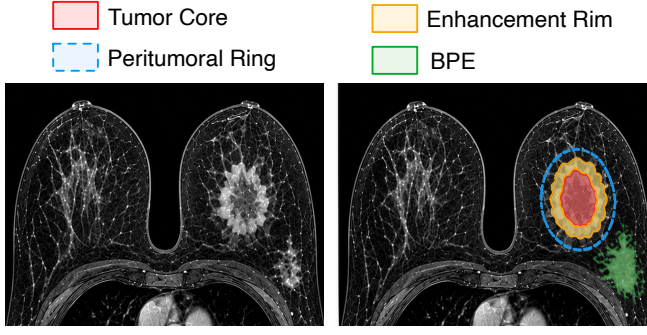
Spatial relations in breast cancer radiogenomics should be constructed from disease-specific regions rather than the whole magnetic resonance imaging (MRI) image. Left: Original breast MRI without regional annotations. Right: The MRI with highlighted disease-specific regions.
